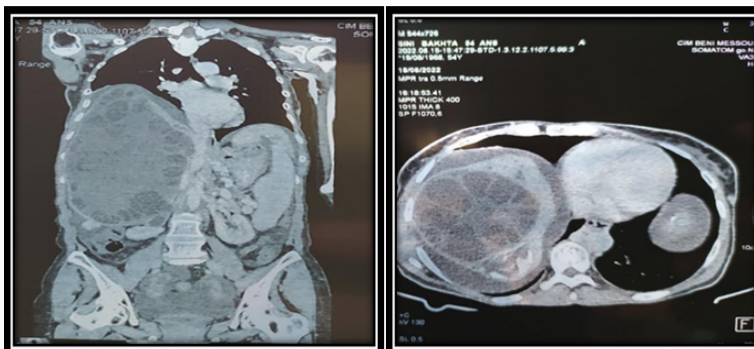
Abdomen and pelvis CT scan revealing a giant solid-cystic mass in the liver (arrowhead), characterized by several daughter-cysts (asterisks), and associated with four other cysts. Axial section (left), coronal section (right).
